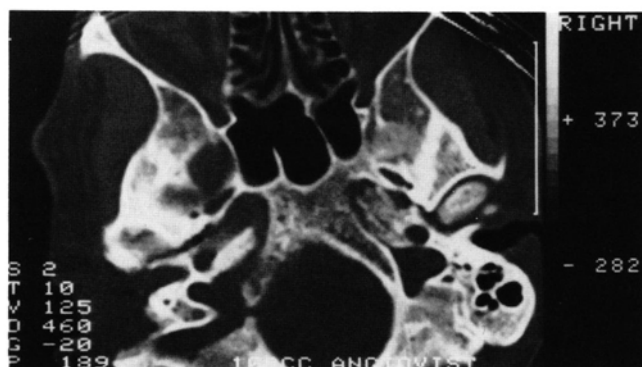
Transaxial CT slicing through the base of the skull, revealing cortical bone destruction on left side of foramen magnum and clivus (left is on reader's left).
